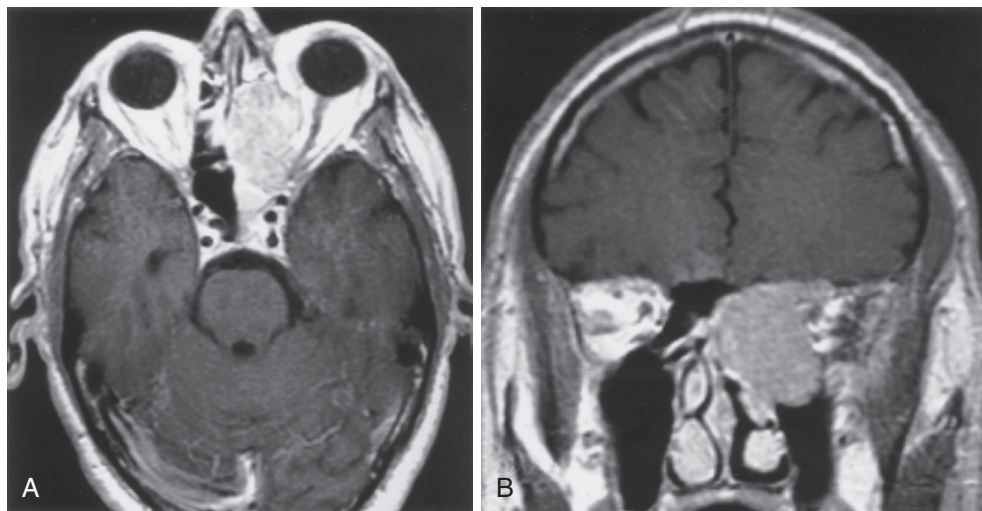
A, Axial MRI scan of patient with adenosquamous carcinoma of the ethmoids involving the orbital fat. Orbital exenteration was necessary. B, Coronal MRI scan of the same patient demonstrating tumor extension to the floor of the anterior cranial fossa. (Courtesy Dr. J. Netterville.)
